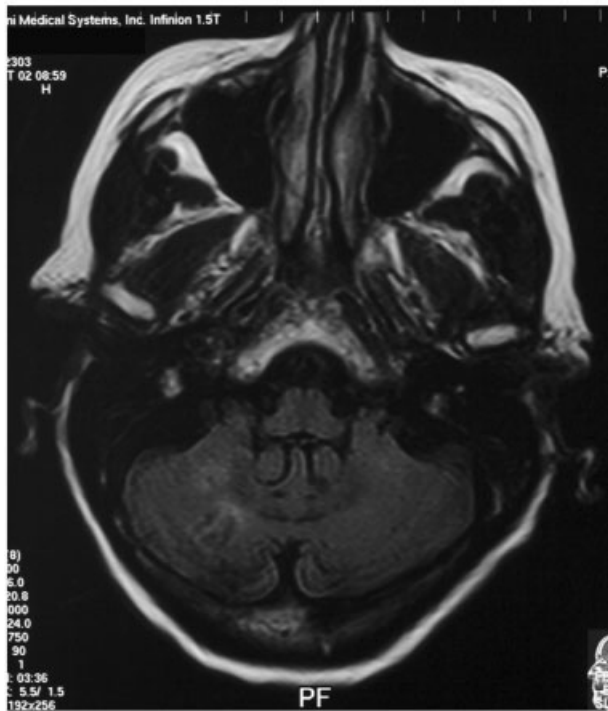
Cranial magnetic resonance image of Subject 1 was performed using a 1.5T magnet (Marconi Medical Systems, UK). Fluid-attenuated inversion recovery images shown were obtained utilizing a TR, 1,800 milliseconds and TE, 96-millisecond weighted sequence and demonstrated high signal in the white matter of the cerebral hemispheres (bottom) and cerebellum (top), and gray and white matter atrophy in the cerebral hemispheres (bottom).
